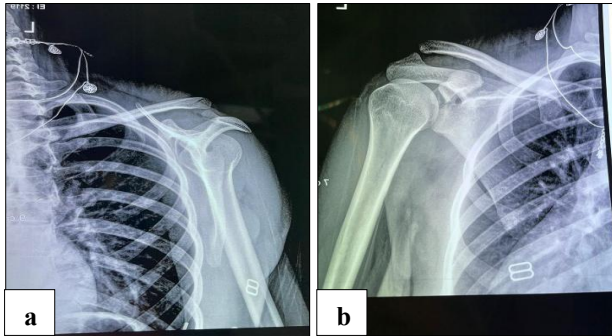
(a and b): Radiographic image.
